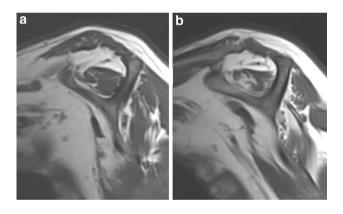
MRI findings in supraspinatus muscle in a patient with re-rupture. Note the increase in both atrophy and fatty degeneration of the muscle before the operation (a) and at the final follow-up (b)
